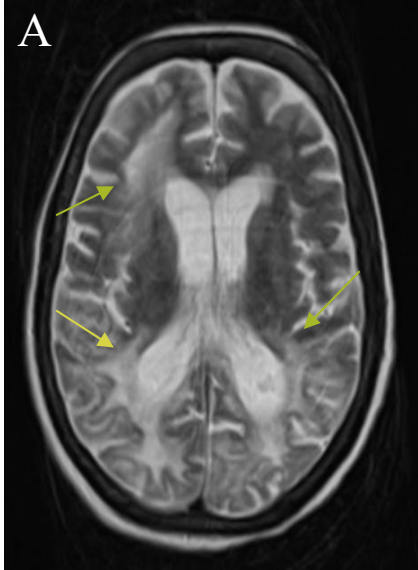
MRI Brain (3 months after diagnosis) axial T2 weighted (A) & fluid-attenuated inversion recovery (FLAIR) sequence (B) showing hyperintensity in bilateral parieto-occipital & right frontal region. No enhancement seen on axial postcontrast T1-weighted sequence (C).
